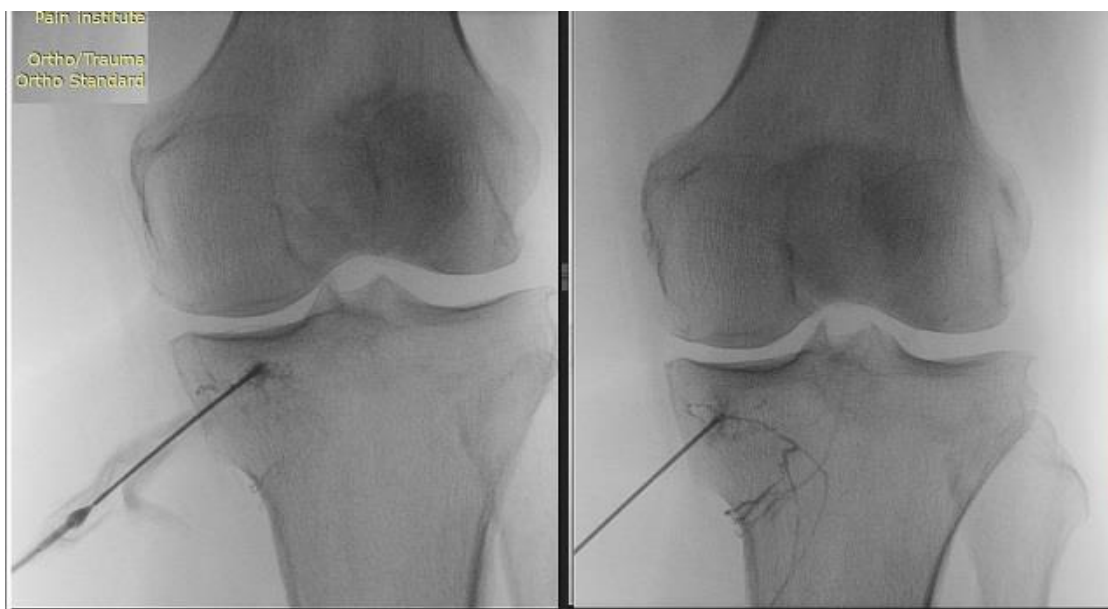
Intraoperative X-ray control of needle position and dye spread.
